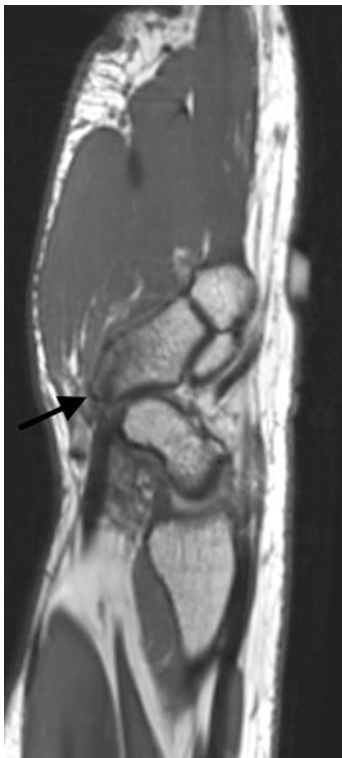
Sagittal T1-weighted MR image demonstrates a non-displaced fracture of tubercle of trapezium
